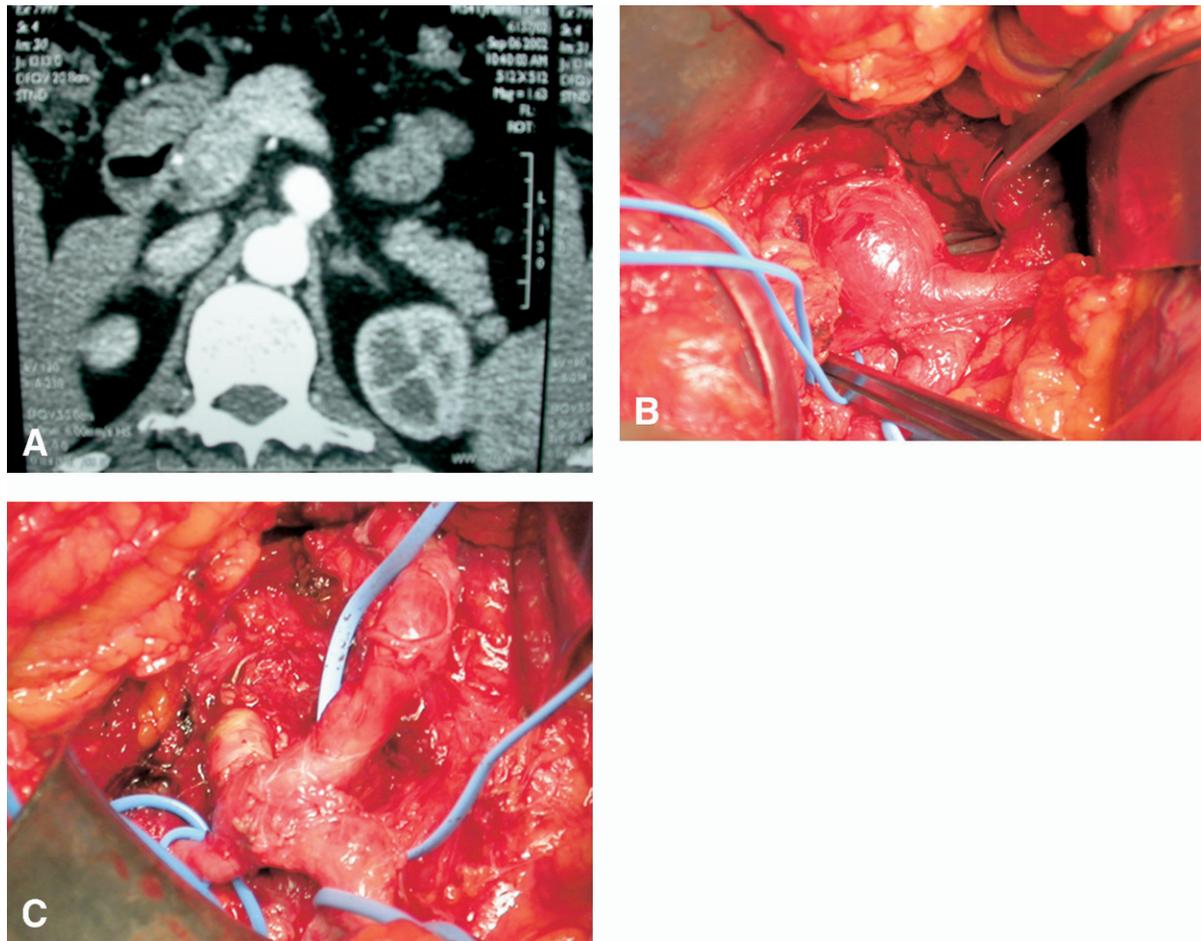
Aneurysm of the celiac trunk. A, Preoperative angio-CT scan. B, Intraoperative finding. C, Primary closure of the celiac trunk.
